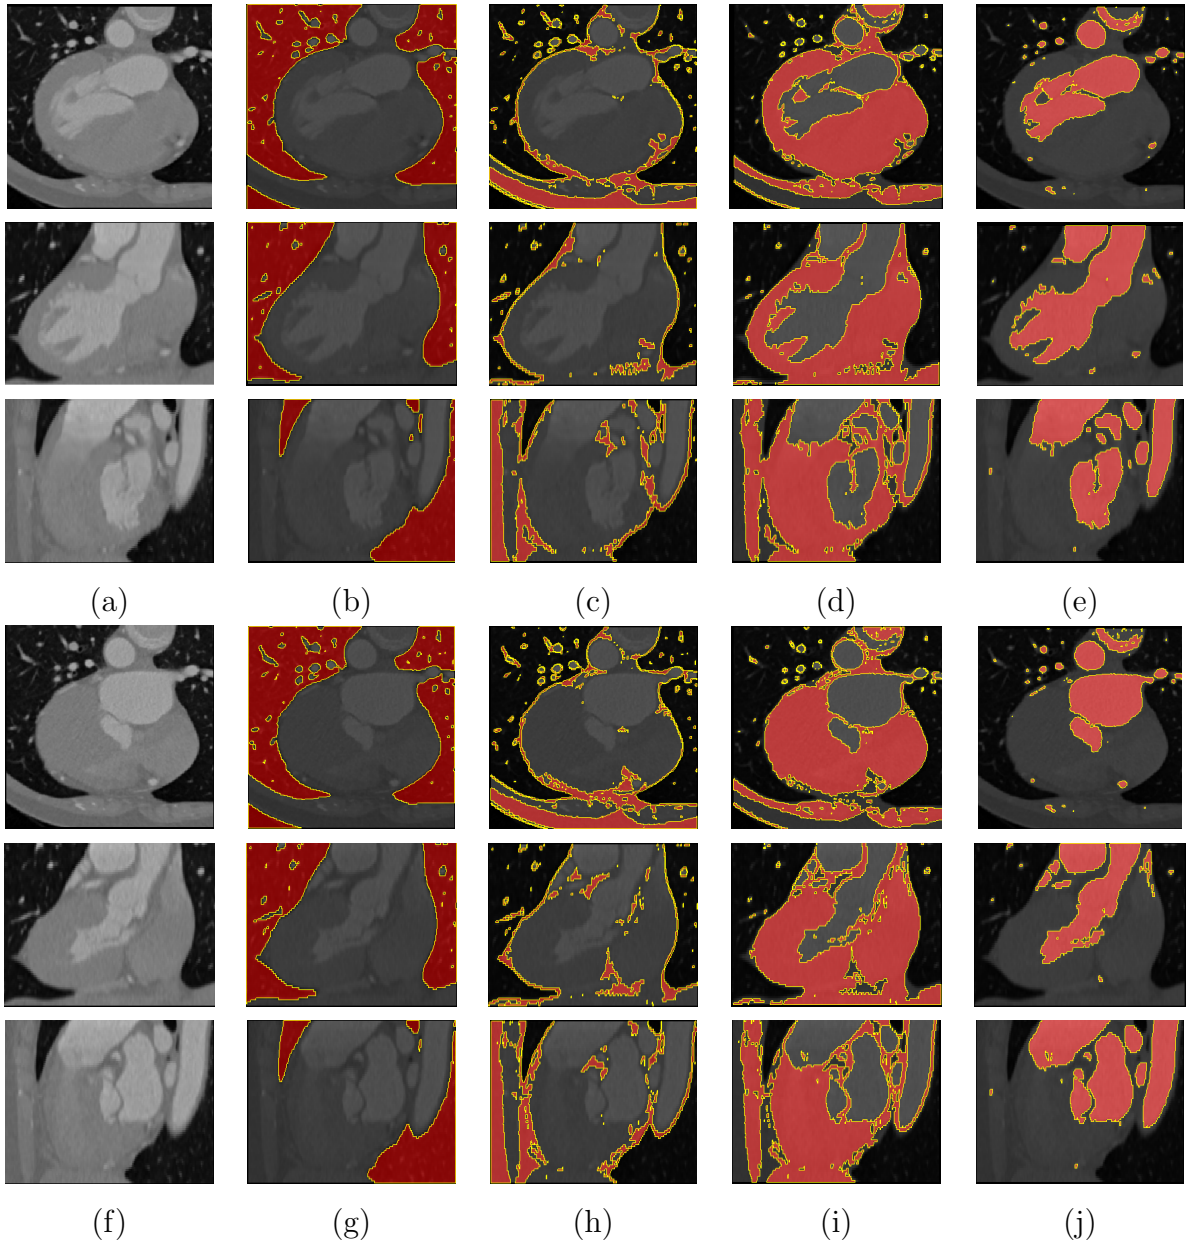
An example of segmentation via 4D thresholding. (a): a region of CTA image at one time frame from a 4D sequence shown in three views after contrast adjustment; (f): the same region of a CTA image at another time frame in three views after contrast adjustment; (b) and (g): Background; (c) and (h): Fatty deposit; (d) and (i): Tissue; (e) and (j): Blood and others. Each class is shown in red within the yellow isolines.
